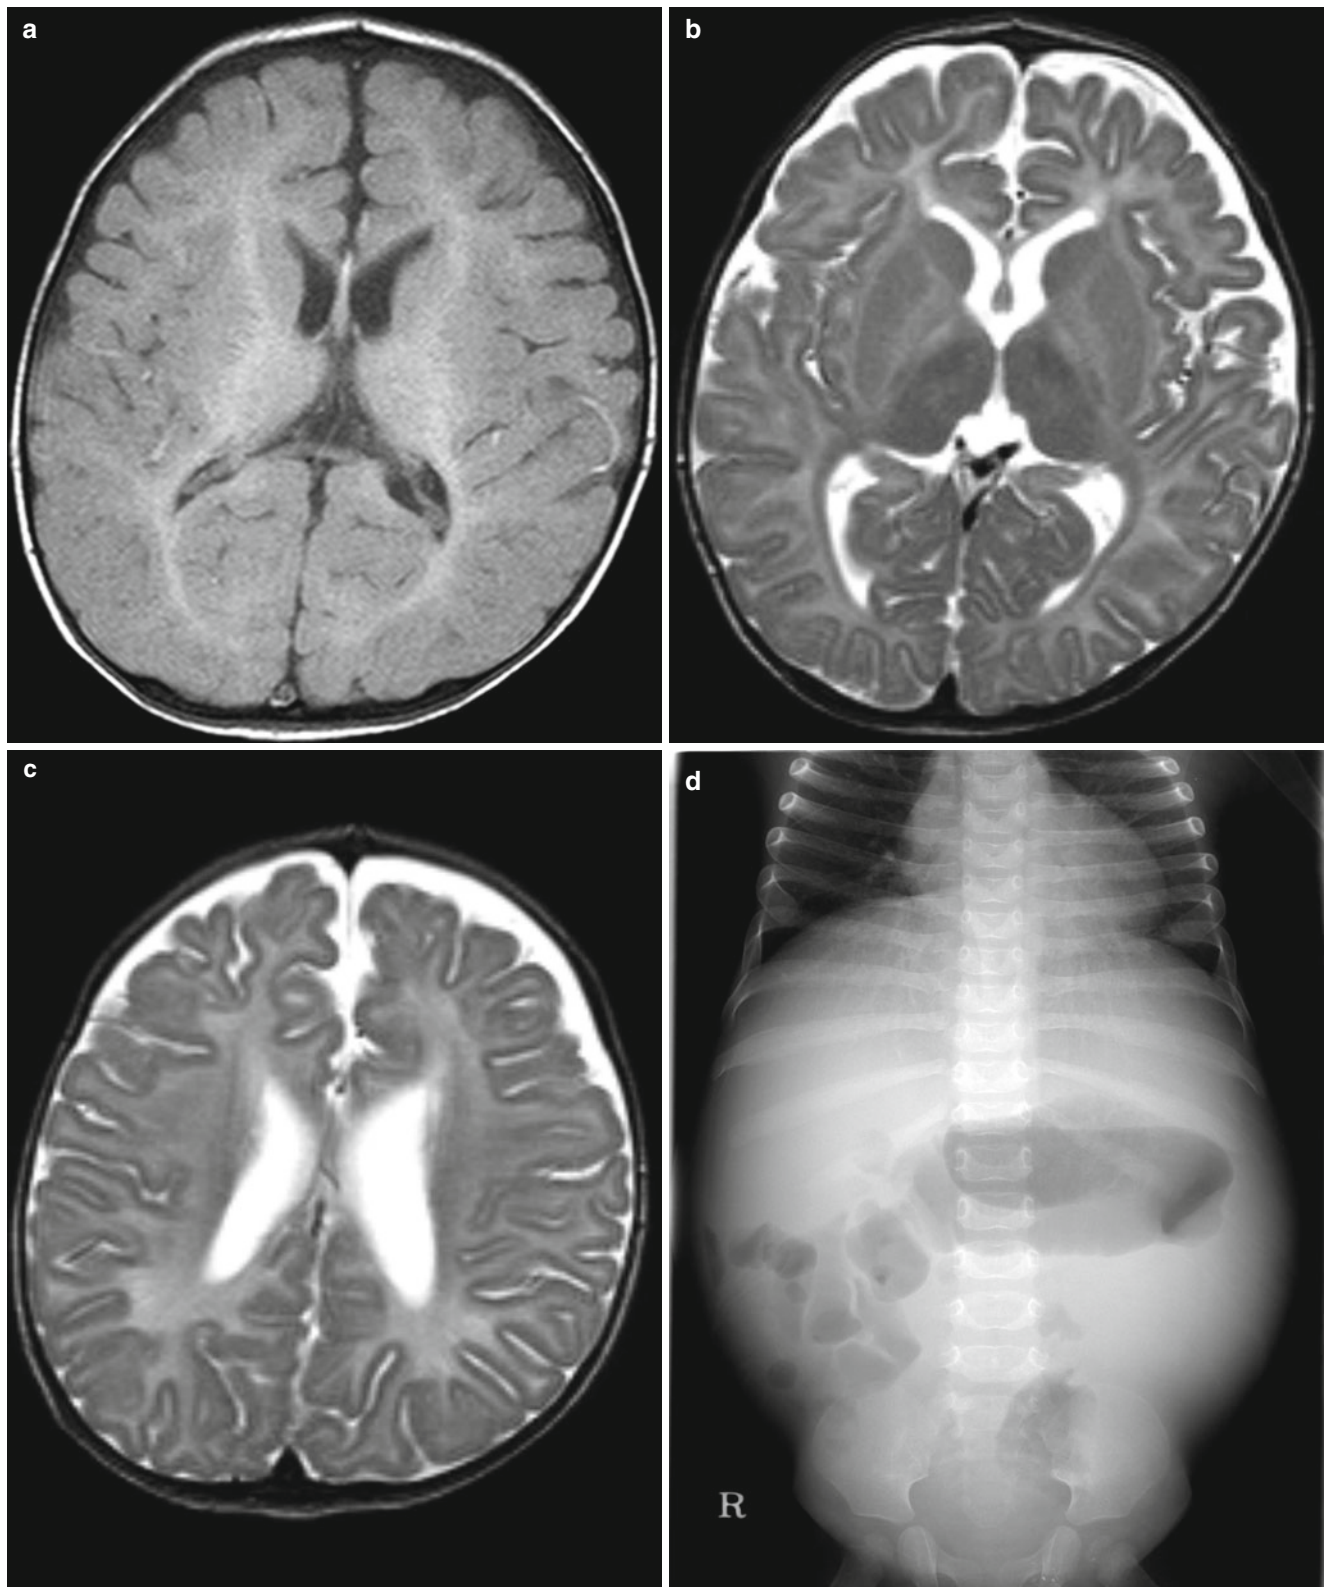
Delayed myelination in Niemann-Pick disease at the age of 15 months. (a) T1-weighted image shows high- signal intensity of the internal capsules. (b, c) T2-weighted images show low-signal intensity of the posterior limb of the internal capsule and optic radiations. The
